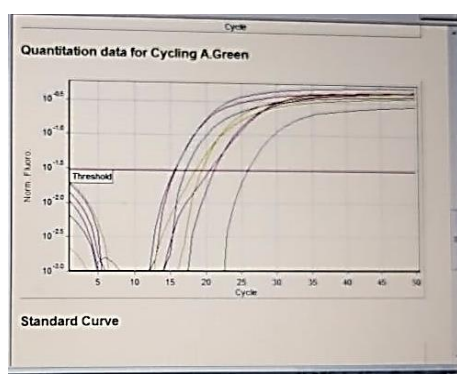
CT analysis of cases and controls
